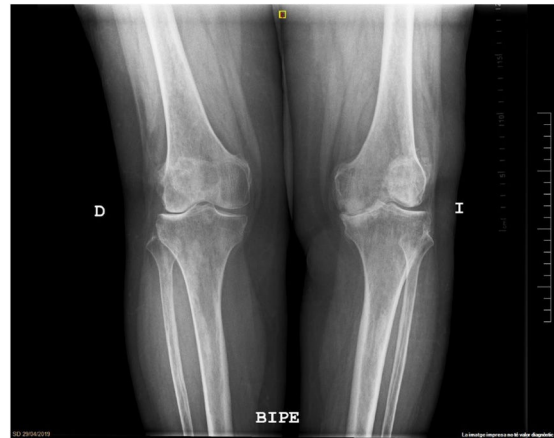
Preoperative X-ray image while standing.
